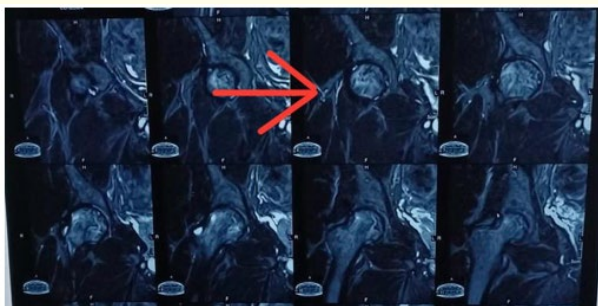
MRI-Pre- operative right.
